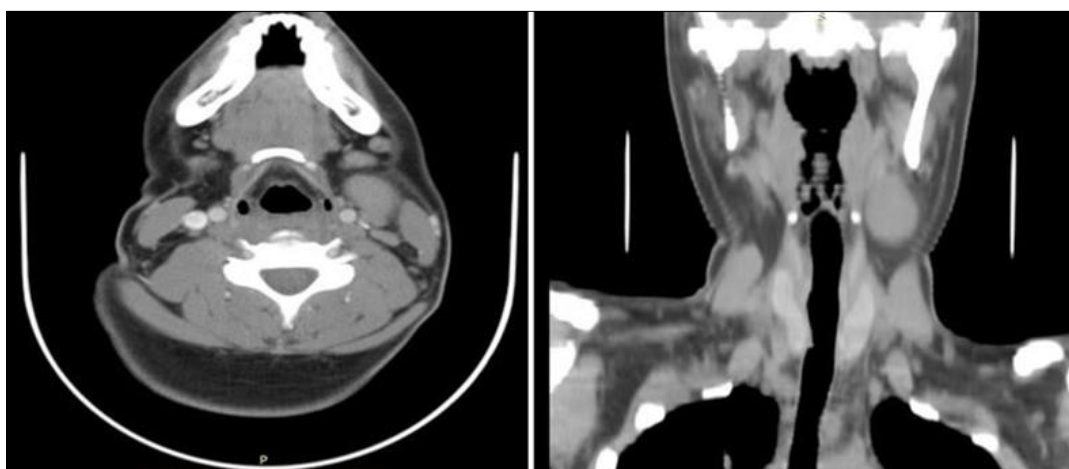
CT-Scan image showing a homogenous left submandibular mass
